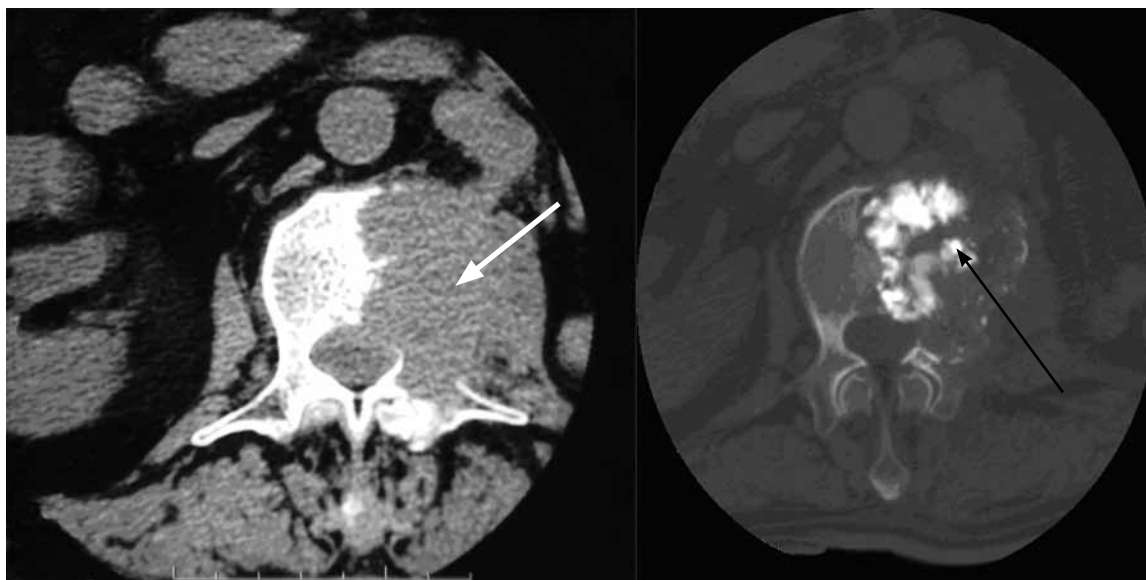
A 64-year-old man of renal cancer with vertebral metastasis. Axial soft tissue windowed CT image shows destructive mass in the left aspect of L2 extending into the paravertebral soft tissues (white arrow); Axial bone windowed CT image post PVP procedure shows cement (black arrow) in the large lytic lesion but no leakage into the spinal canal.
